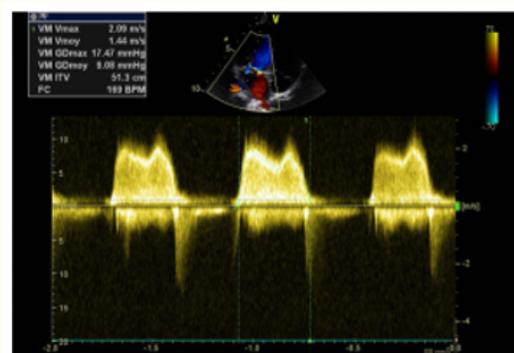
Continuous Doppler quantifying the peak and mean transmitral gradients.
